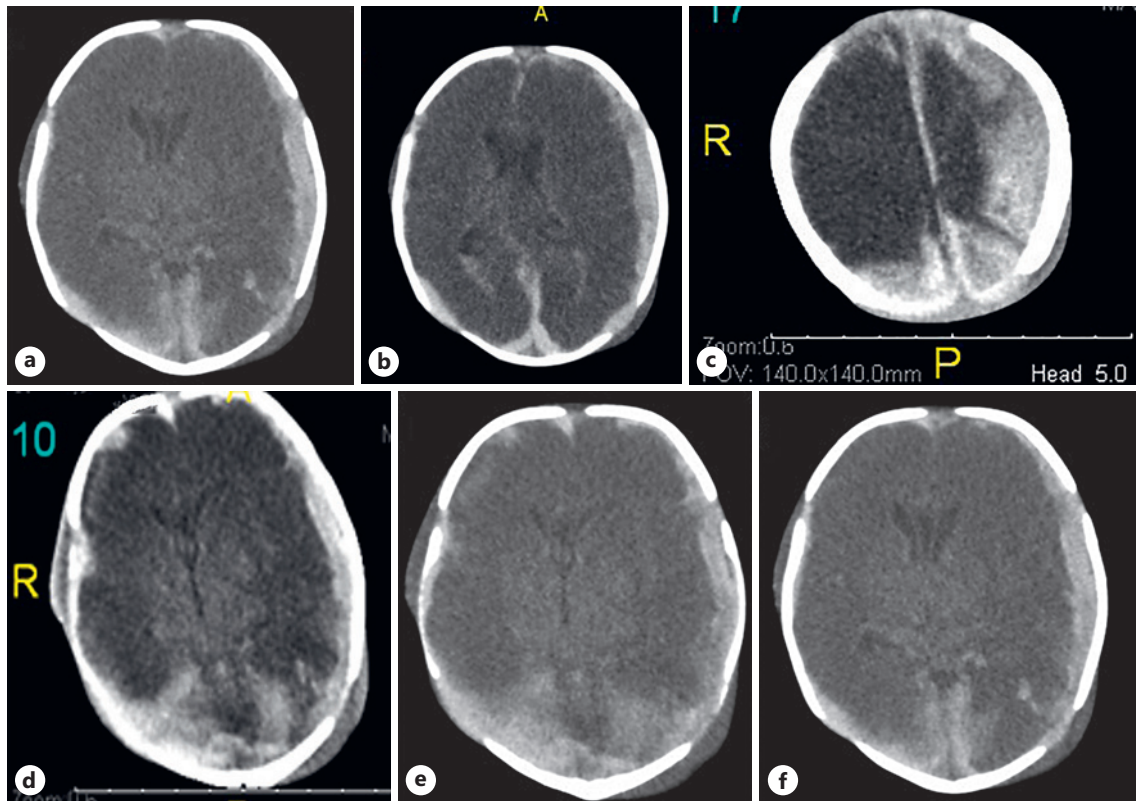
a-f Head computed tomography (CT) scan: head CT on day 2 of life showing significant bilateral SDH surrounding almost the whole left hemisphere with extension to the tentorium and posterior interhemispheric fissure as well as the occipital horn of the right lateral ventricle. Also, linear hyperdense lesions are
